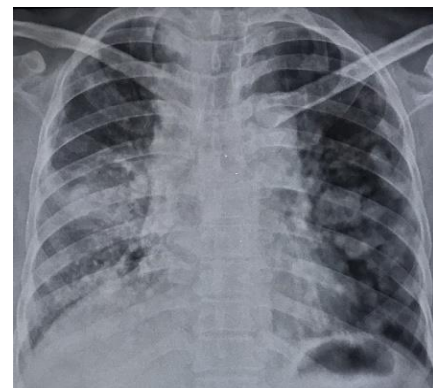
chest x-ray posteroanterior view showing predominant parenchymal abnormalities in bilateral middle and lower lung
